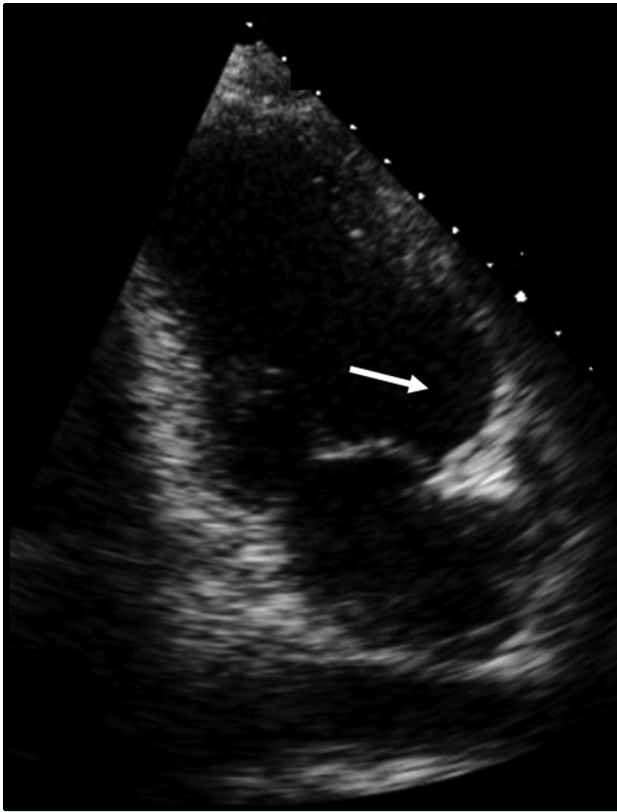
Transthoracic echocardiogram of a 28-year-old man (patient 29) who had syncope and repetitive monomorphic ventricular tachycardia at presentation, showing a congenital anterolateral left ventricular aneurysm (arrow) on an apical 2-chamber view.
